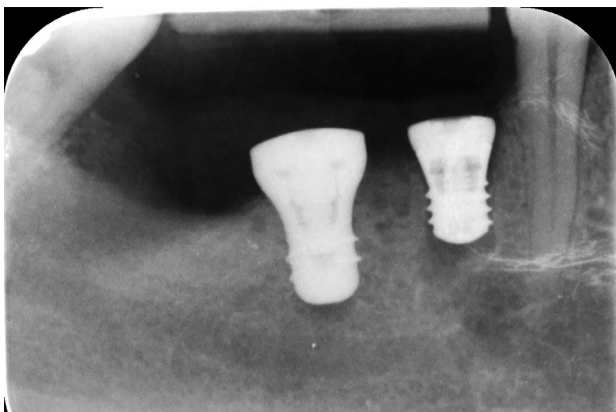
Periapical X-Ray at the end of the surgery.
